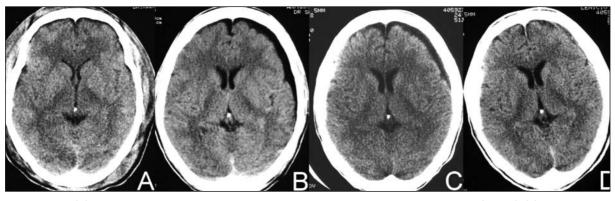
Case 4. (A) CT scan on admission showing subarachnoid hemorrhage and cerebral edema (1st day). (B) CT scan showing left frontoparietal subdural hygroma with probable compression of the underlying brain (26th day). (C) CT scan showing enhanced hygroma density (50th day). (D) CT scan showing reduction in the subdural collection, with probable neomembrane and septation (240th day).
